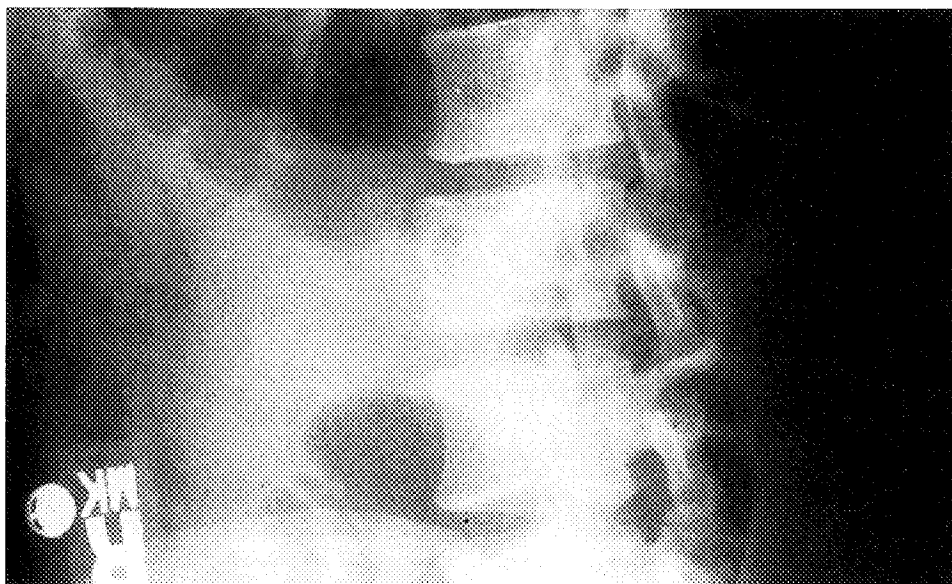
Oblique radiograph of the lumbar spine showing the enlarged pedicle of the third lumbar vertebra.
